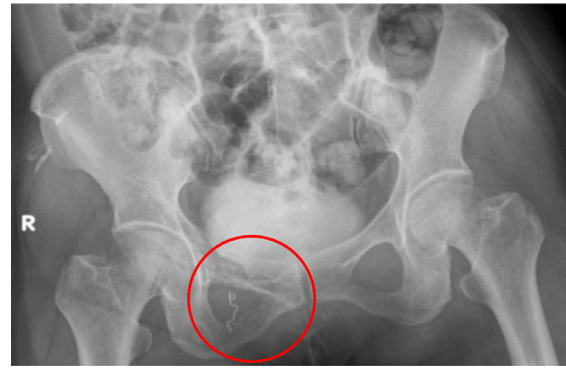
On the pelvic radiograph, osteolytic lesions, affecting both the superior and inferior pubic ramus (circle), characterized by an indistinct, irregular margin without periosteal reaction visualized.
